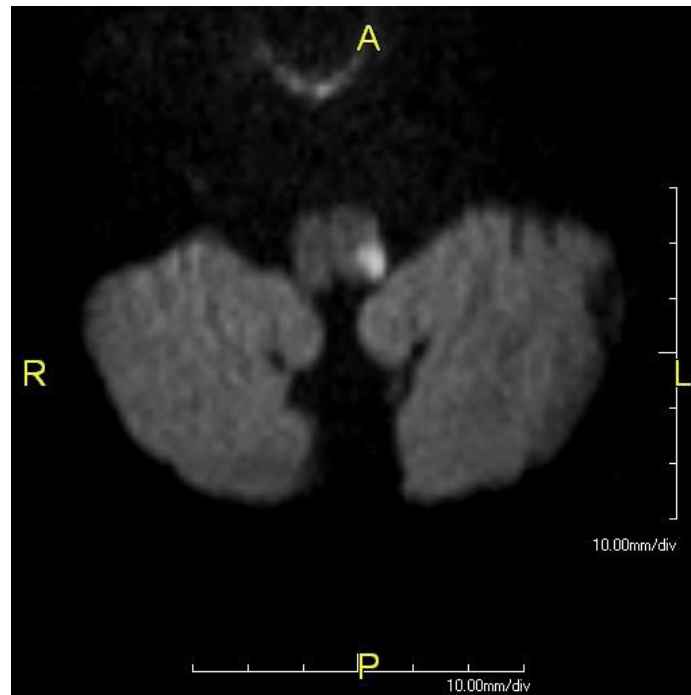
Diffusion-weighted MRI (axial) demonstrating restricted diffusion in the lateral medulla - the radiological signature of lateral medullary (Wallenberg) syndrome from PICA territory infarction.
